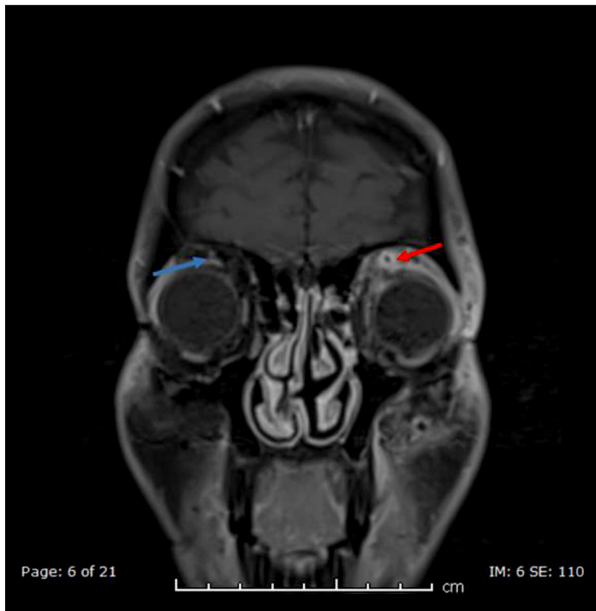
Computed tomography post contrast coronal imaging showing left sided (red arrow) superior ophthalmic filling defect suggestive of venous thrombosis.
